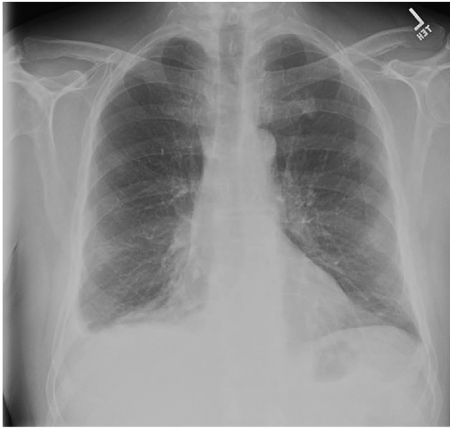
Admission Plain radiograph with small pleural effusion.
